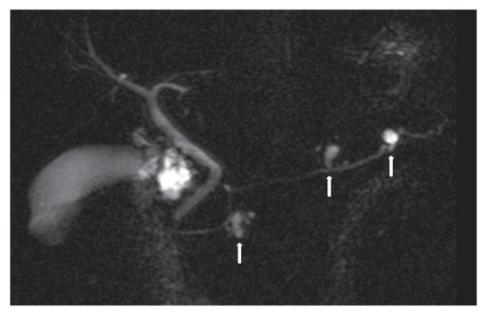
MRI image of multifocal branch type intraductal mucinous neoplasia in a patient with familial pancreatic cancer highlighted by the white arrows
